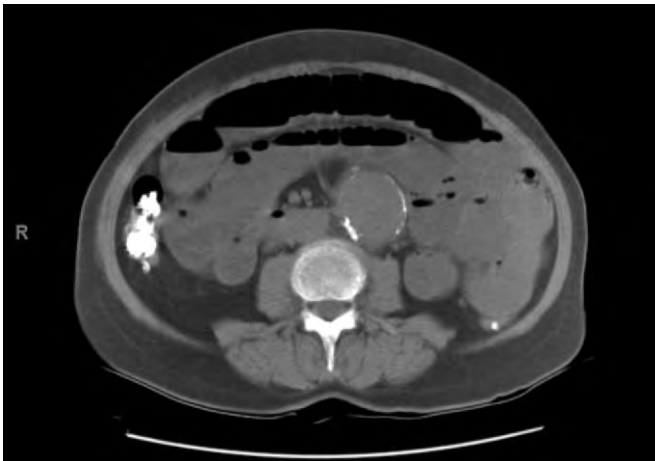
Computed tomography scan of the abdomen showing high-grade partial distal small bowel obstruction.
